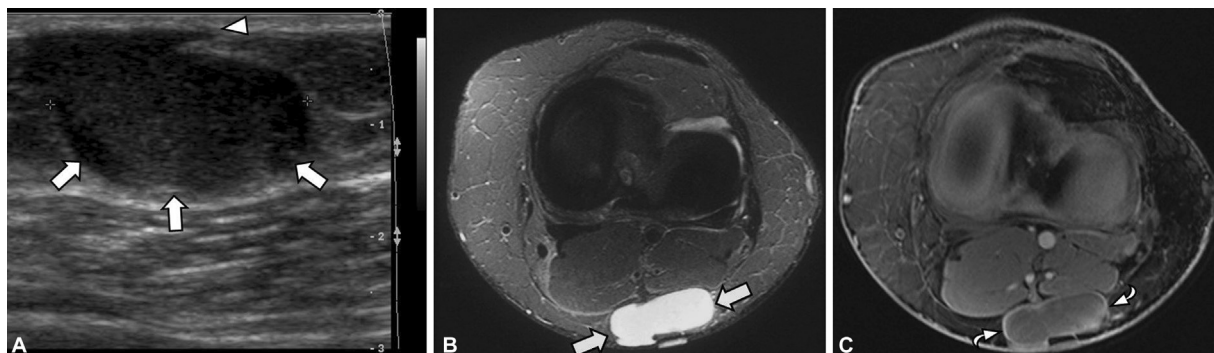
A 48-year-old female with mass (arrows) in the popliteal fossa. (A) Ultrasound image demonstrates a cystic hypoechoic mass with a tract (arrowhead) extending to the epidermis. (B) Axial short-tau inversion recovery (STIR) magnetic resonance (MR) image shows a hyperintense lesion also with extension to the skin surface and thin peripheral enhancement on the (C) axial T1 fat-suppressed postcontrast MR image. Epidermoid cysts should have a connection to the skin surface and can have hyperechoic material differing them from a synovial cyst.
